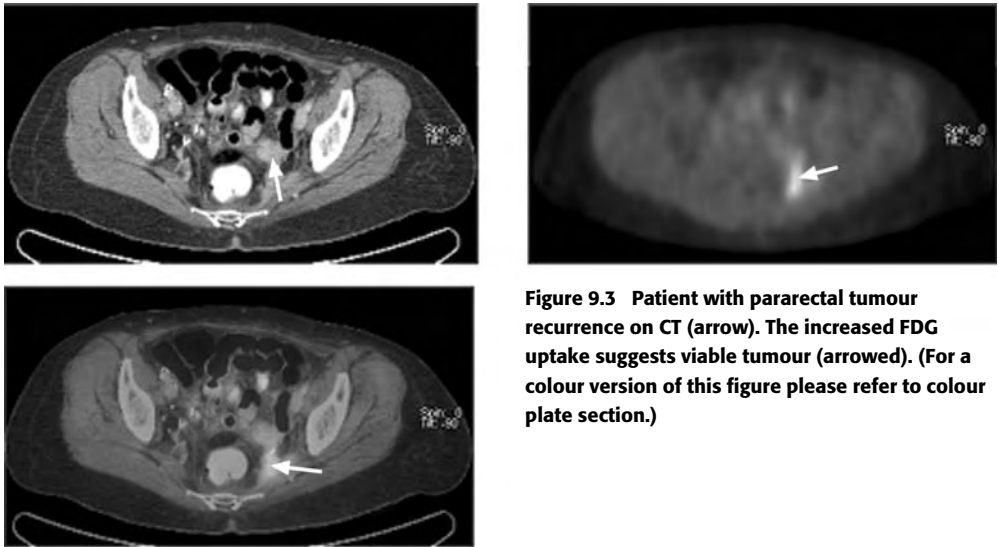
Patient with pararectal tumour recurrence on CT (arrow). The increased FDG uptake suggests viable tumour (arrowed). (For a colour version of this figure please refer to colour plate section.)
